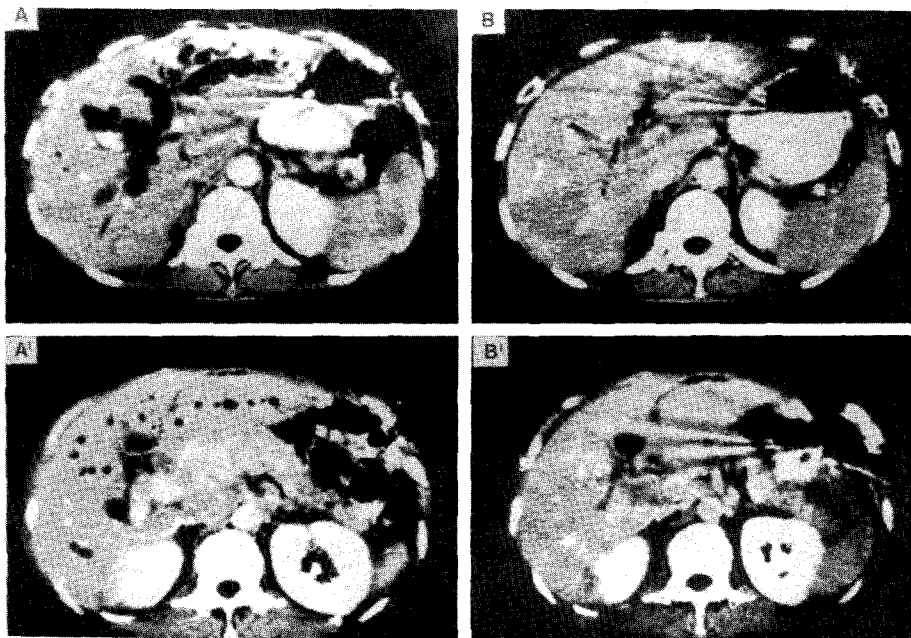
Pretreatment CT scan shows markedly dilated intrahepatic biliary trees (A) due to metastatic mass in the peripancreatic area. (A') After 4500 cGy of external irradiation and 12 times of hyperthermia the dilated intrahepatic biliary trees and peripancreatic mass are almost normalized. (B, B')
